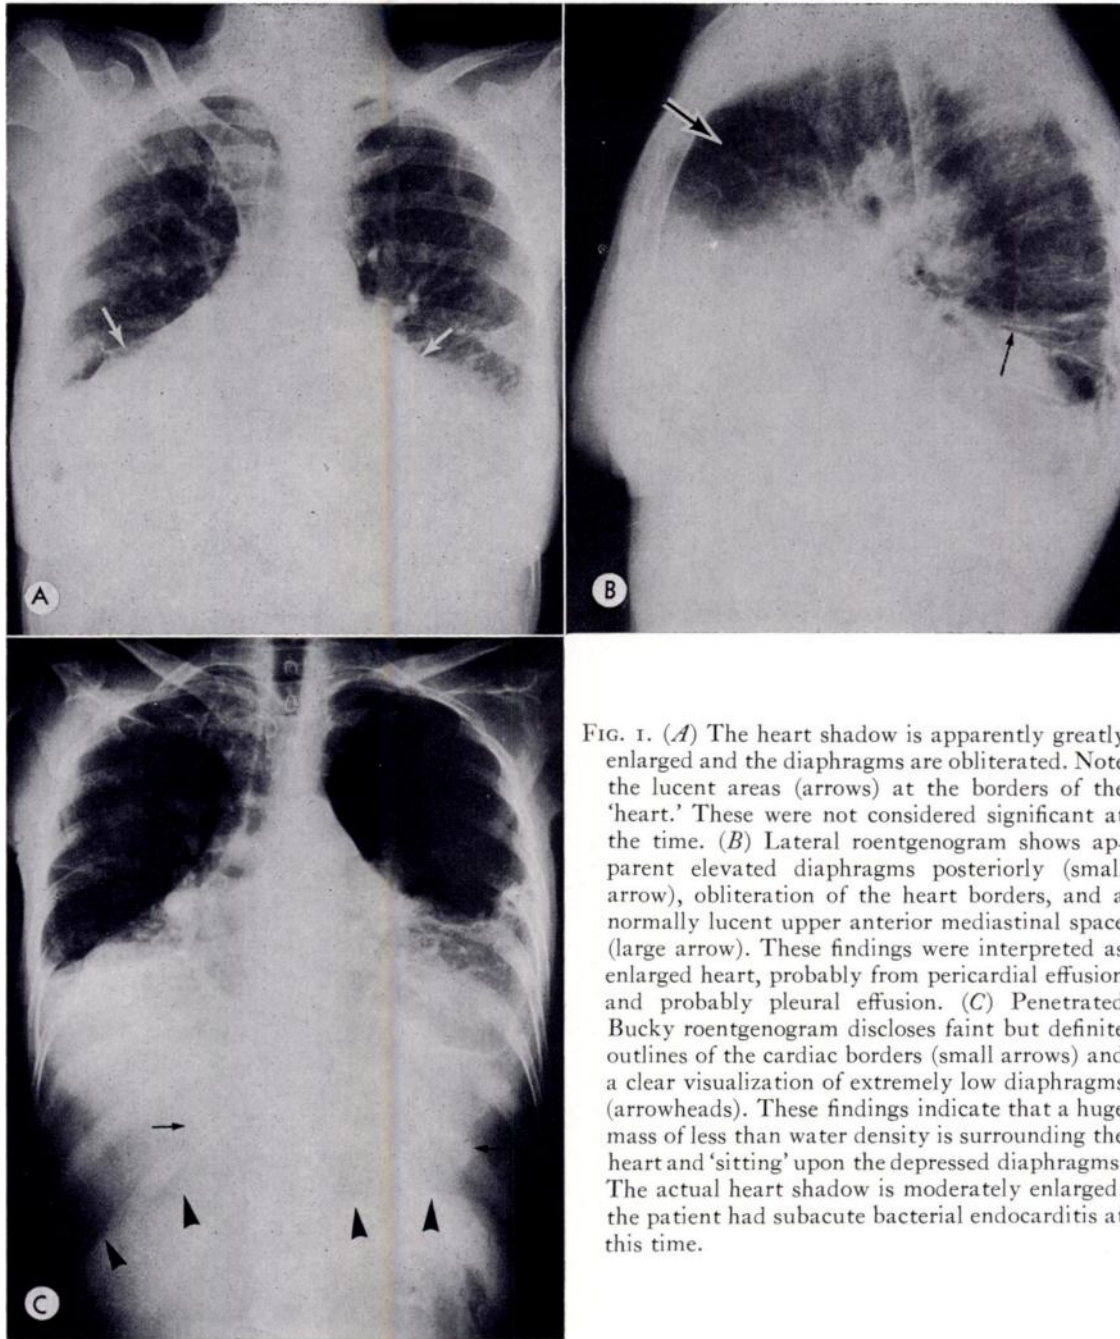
(A) The heart shadow is apparently greatly enlarged and the diaphragms are obliterated. Note the lucent areas (arrows) at the borders of the 'heart.' These were not considered significant at the time. (B) Lateral roentgenogram shows apparent elevated diaphragms posteriorly (small arrow), obliteration of the heart borders, and a normally lucent upper anterior mediastinal space (large arrow). These findings were interpreted as enlarged heart, probably from pericardial effusion and probably pleural effusion. (C) Penetrated Bucky roentgenogram discloses faint but definite outlines of the cardiac borders (small arrows) and a clear visualization of extremely low diaphragms (arrowheads). These findings indicate that a huge mass of less than water density is surrounding the heart and 'sitting' upon the depressed diaphragms. The actual heart shadow is moderately enlarged; the patient had subacute bacterial endocarditis at this time.
